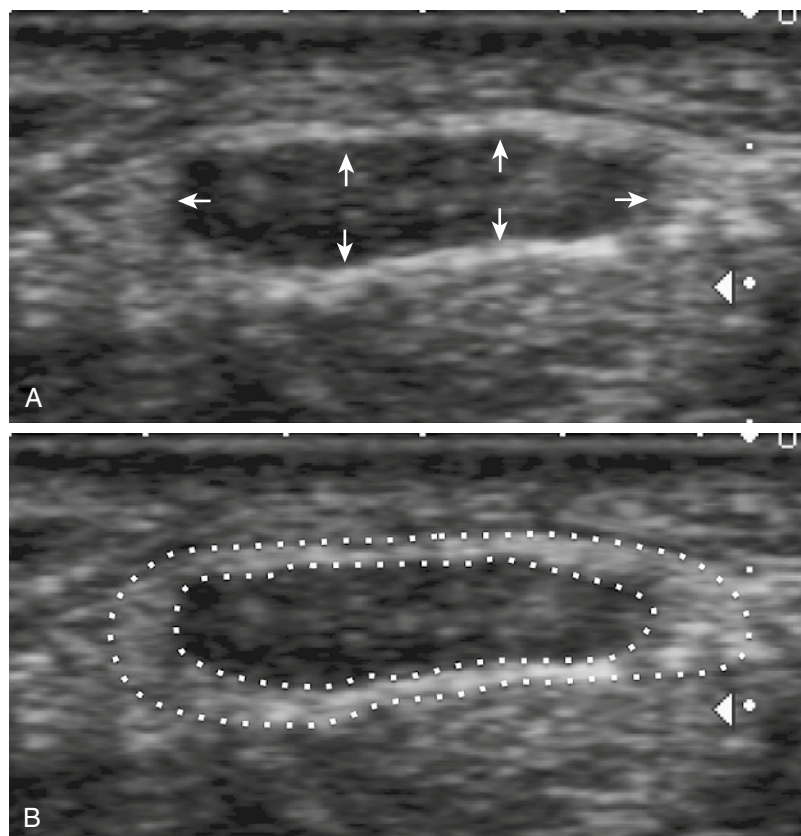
ENLARGED MEDIAN NERVE. Twice the same short-axis, 5- to 14-MHz ultrasound image is shown for a pathologically enlarged median nerve at the carpal tunnel level. A, The outer limit of the hypoechoic area of the nerve (*arrows*) should be used when measuring the nerve's cross-sectional area (CSA). B, The hyperechoic rim (area between the *dotted lines*) marks the outer limit of the nerve and corresponds to the external epineurium; it should not be included in the CSA measure because it can be difficult to distinguish its limit from the surrounding fat.
